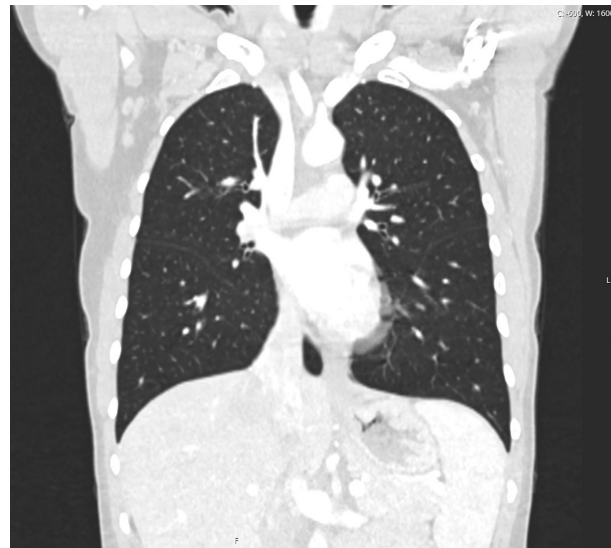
Chest CT shows clear lungs with no evidence of interstitial changes, hilar, or mediastinal lymphadenopathy.
